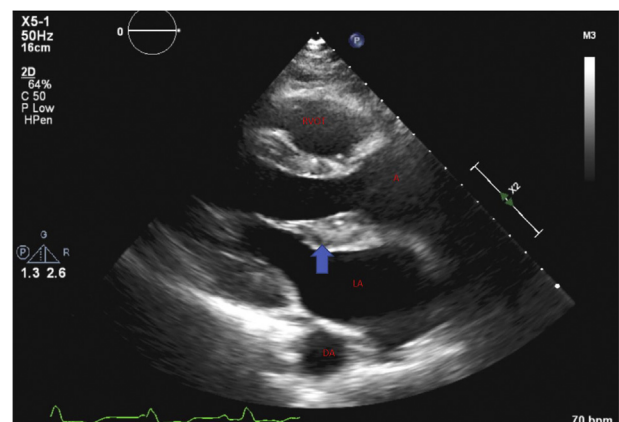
Parasternal long-axis echocardiographic view showing homogenous thickening of aortic valvular annulus, commissures, subaortic area, and mitral valve (arrow). A, Aorta; DA, descending aorta; LA, left atrium; RVOT, right ventricular outflow tract.
